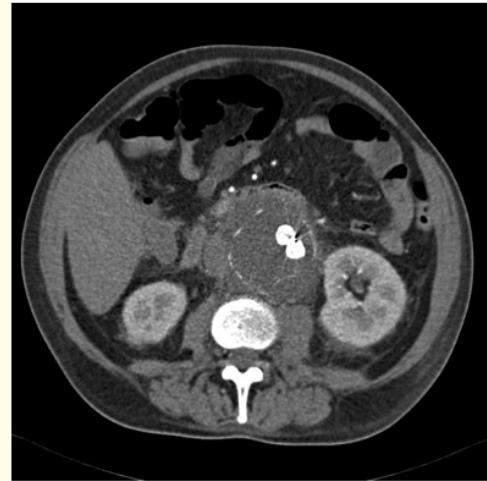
The development and a retroperitoneal collection increasing from a CT-scan to another.
